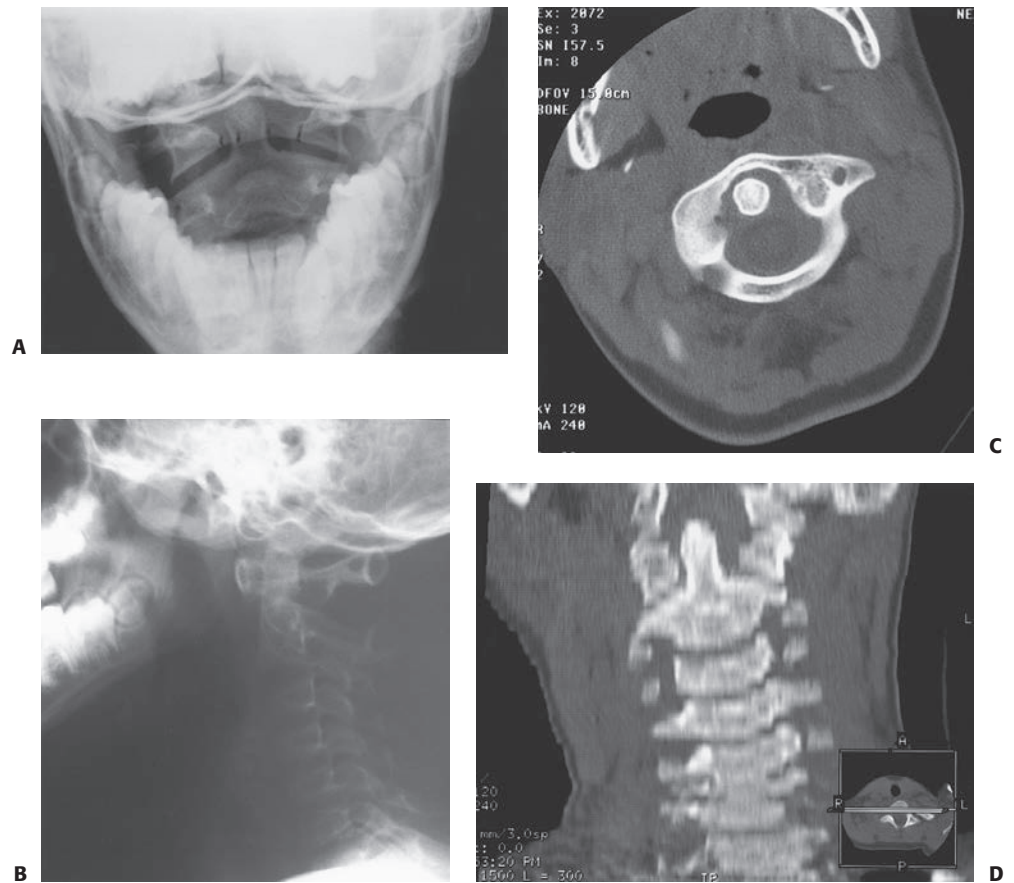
A, B: Odontoid view and lateral cervical spine radiograph of rotary subluxation of C1 on C2. C: Note the asymmetry on the open-mouth odontoid view. D: CT and CT reconstruction documenting rotary subluxation.
